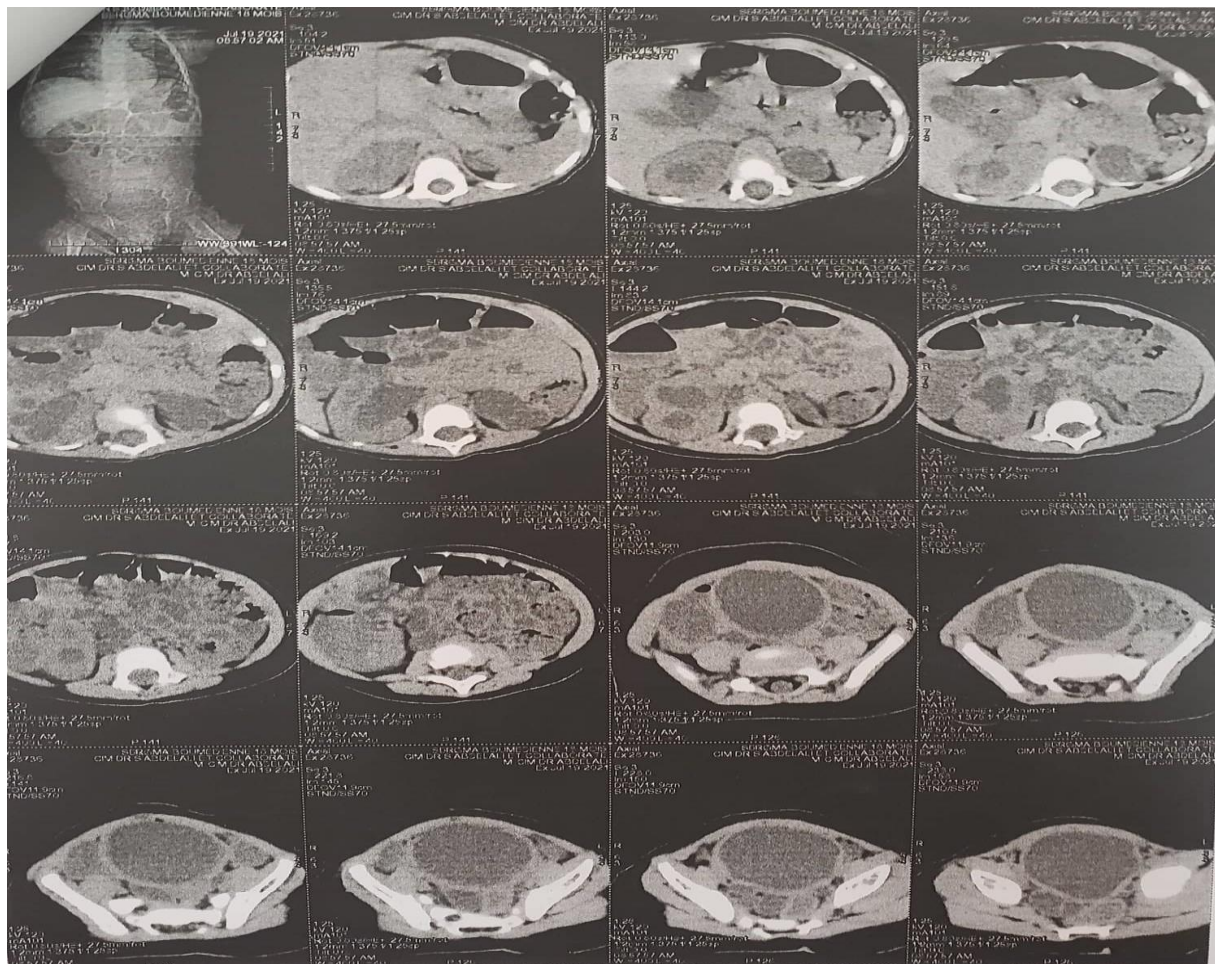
CT scan showing a major left hydronephrosis.
